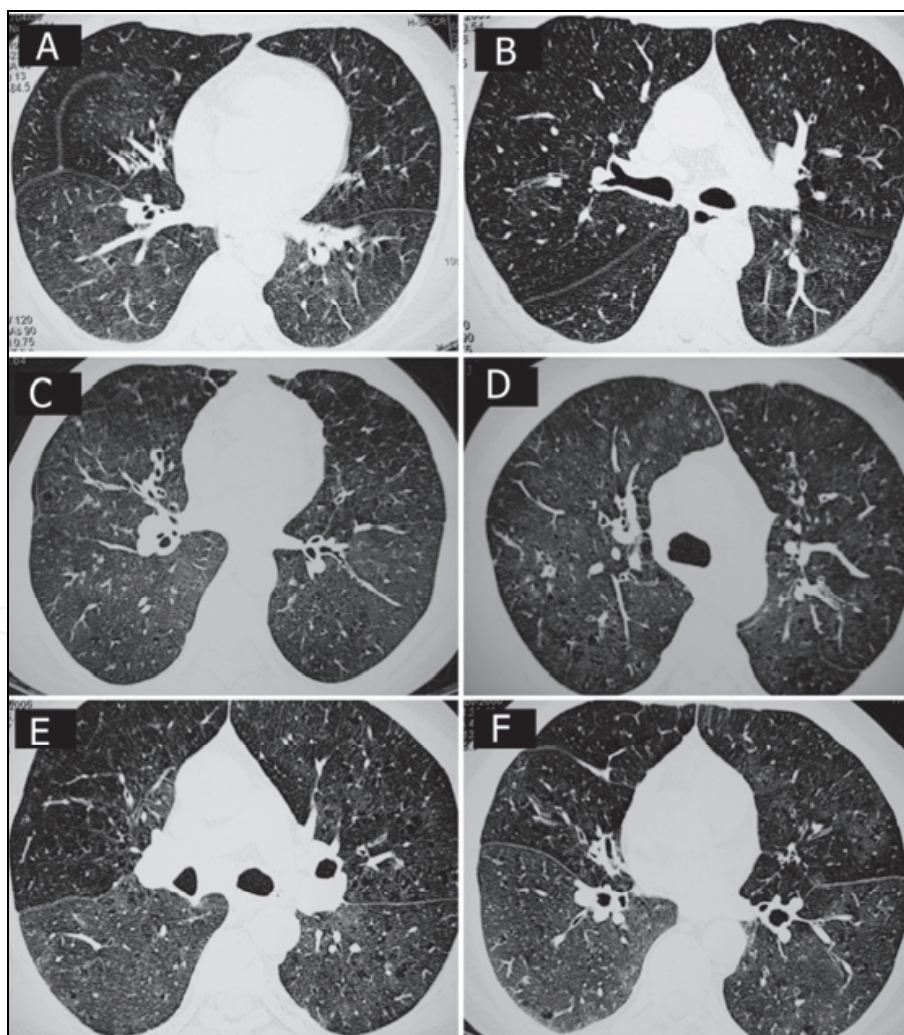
HRCT scans showing non-homogenous lung density – a cardinal feature of mosaic attenuation pattern (A-F) observed on HRCT scan obtained from different COPD patients.
